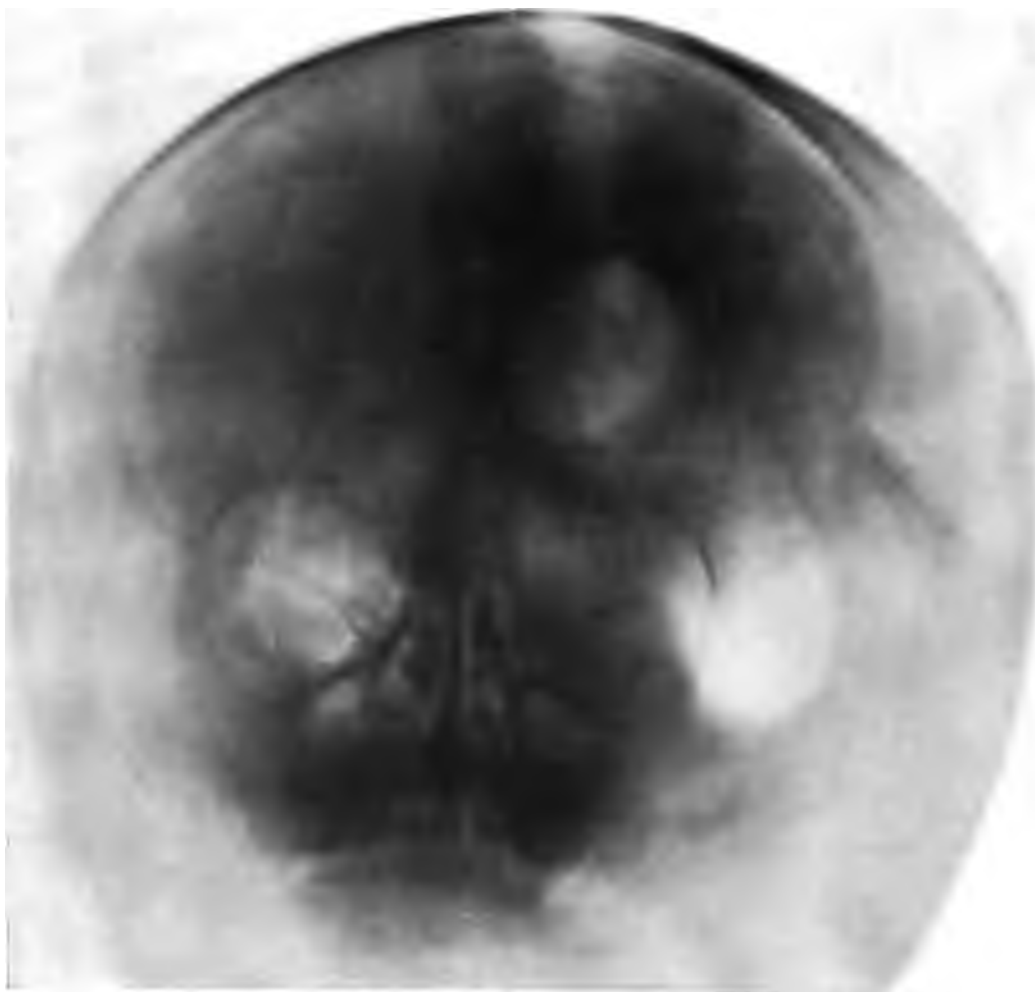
Anteroposterior ventriculogram of Fig. 3. Note the unequal distribution of air on the two sides. The ventricle shadow is greatest in the body and descending horns, owing to the depth of the column of air. The posterior curved and ventricular part of the ventricle shows as a lighter shadow, communicating the two deeper shadows. The shadow is lighter because the smaller column of air gives relatively less penetration to the roentgen rays. The curvature of the ventricles and the perspective are brought out by stereoscopic vision. (a) third ventricle.
